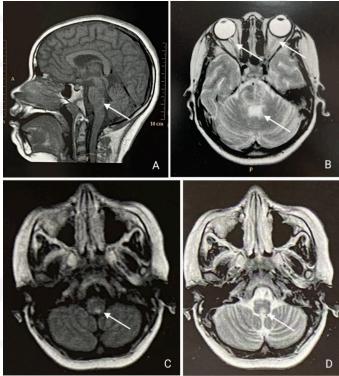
a. Sagittal T1 image showing diffuse and heterogeneous signal affecting the brainstem (arrow) b. Hyperintensity in the area postrema and optic neuritis (arrows) c. Hyperintensity in the medulla oblongata adjacent to the fourth ventricle in FLAIR (arrow) d. Hyperintensity in the medulla oblongata adjacent to the fourth ventricle in T2 (arrow).
